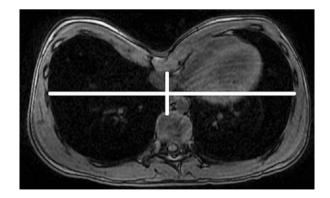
Axial computed tomography image demonstrating the calculation of the Haller index by dividing the internal lateral transverse thoracic diameter by the anteroposterior diameter
